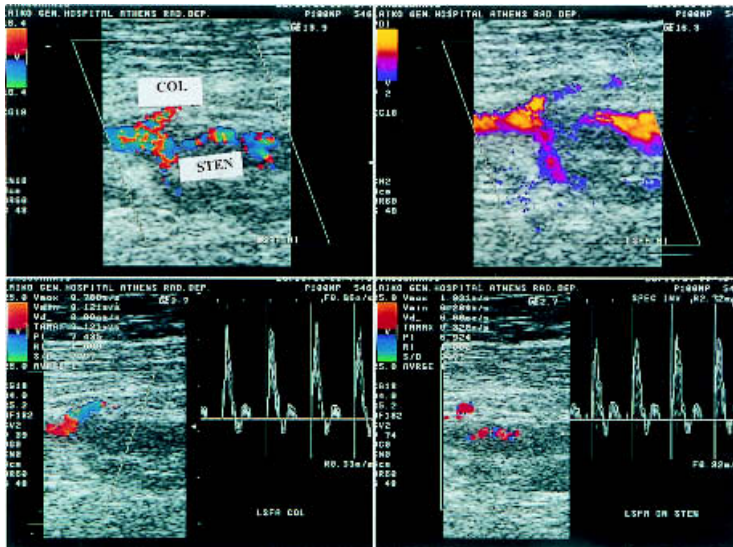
In the left upper panel a significant stenosis (STEN) of the left superficial femoral artery with collateral circulation development (COL) is shown. Note (left lower panel) the triphasic spectral waveform in the collateral vessel and that the peak systolic velocity is 78 cm/s, which is too high for such a vessel. In the area of the femoral artery stenosis, the peak systolic velocity is high (193 cm/s) and the waveform is triphasic, but blood flow during diastole is low, as seen from the short duration of the reverse flow (right lower panel). Adjacent to the spectral waveform, a color duplex scan of the artery with the stenosis is shown. These findings suggest the presence of stenosis of approximately 50–80%. In the upper right panel a dynamic Doppler recording is shown, which gives a clearer image of the collateral vessels. (Courtesy of C. Revenas)
